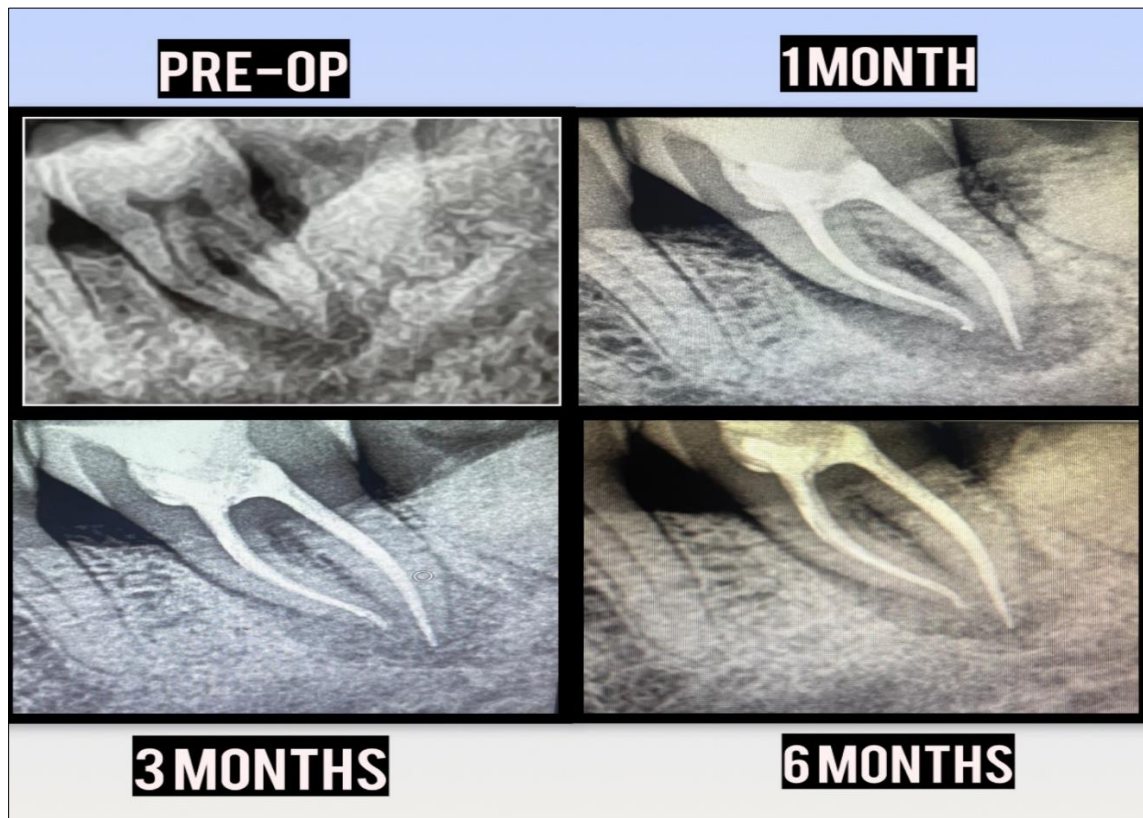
Radiographic Changes from Base Line to 6 Months
